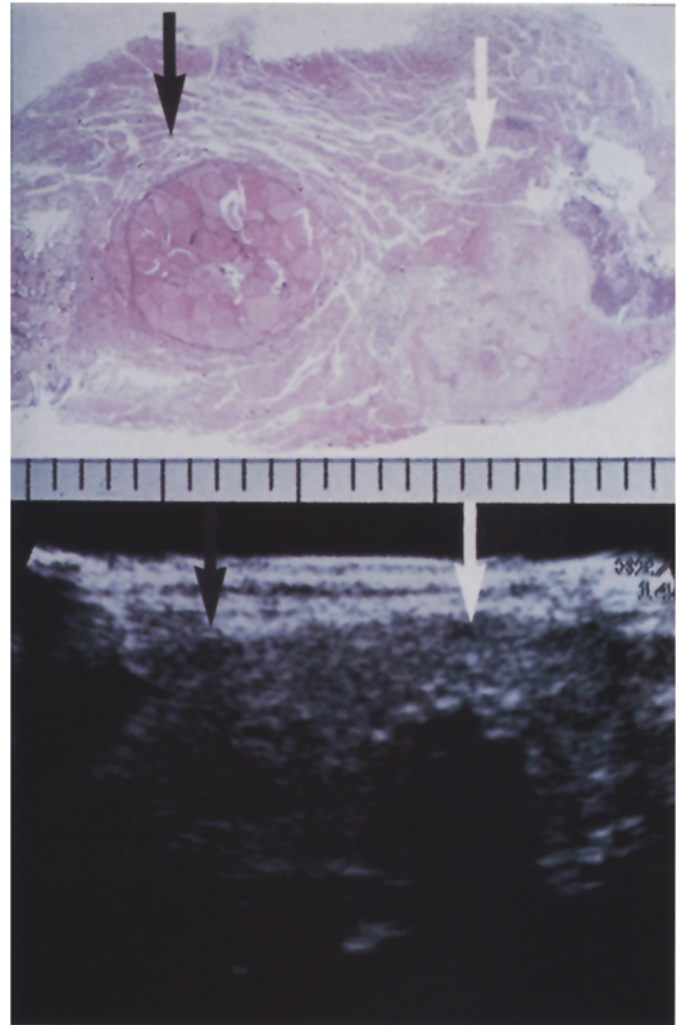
Case associated with a benign (adenomatous) nodule and papillary carcinoma. Black arrow: benign nodules present for a long time. White arrow: unexpected nodule that turned out to be papillary carcinoma by ultrasound-guided FNAB. The lower picture corresponds to the ultrasound finding of these nodules.
